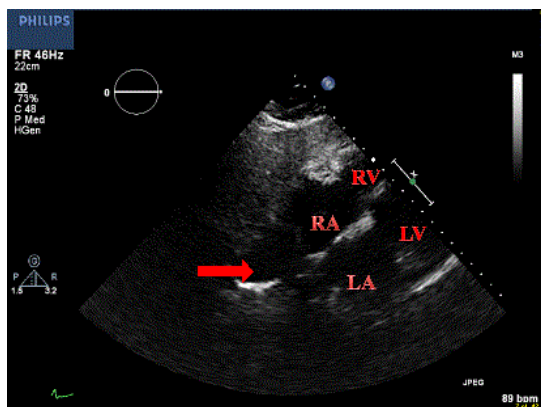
Subcostal echocardiographic view revealed 4.1 x 4.4 cm² cystic structure (red arrow) adjacent to the right atrium, which may represent pericardial cyst. 2D echocardiogram was performed using Philips iE33 xMatrix with X5-1 probe.
